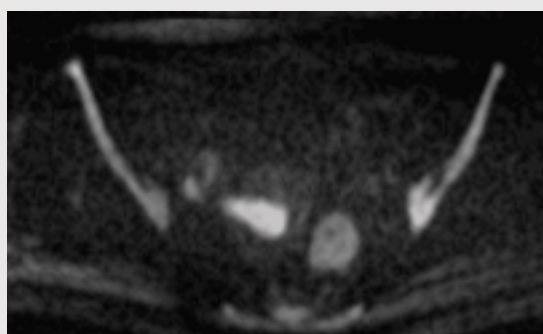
Diffusion-weighted image – DWI ($b = 3000$)
